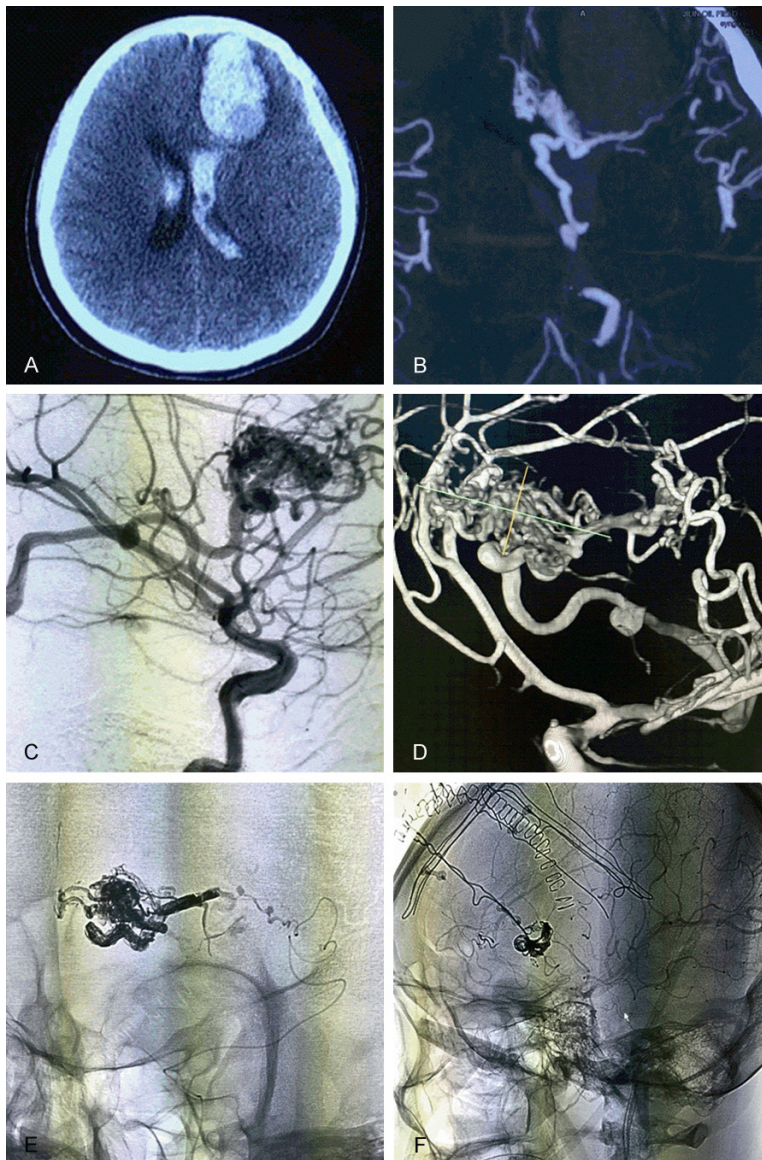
Images from case 1. A: Head CT shows hemorrhage of the left frontal lobe that breaks into the ventricle; B: Head CTA shows an AVM in the frontal lobe, which is fed by the MMA and ACA and drains into the ventricle; C, D: Head DSA examination shows that the AVM was introduced into the straight sinus via the internal cerebral vein, and an aneurysm was found in the blood supply artery; E: Onyx glue was used to embolize most of the AVM; F: Angiography after the craniotomy removal of the AVM shows the venous drainage end of the residual embolism, but an AVM did not develop.
